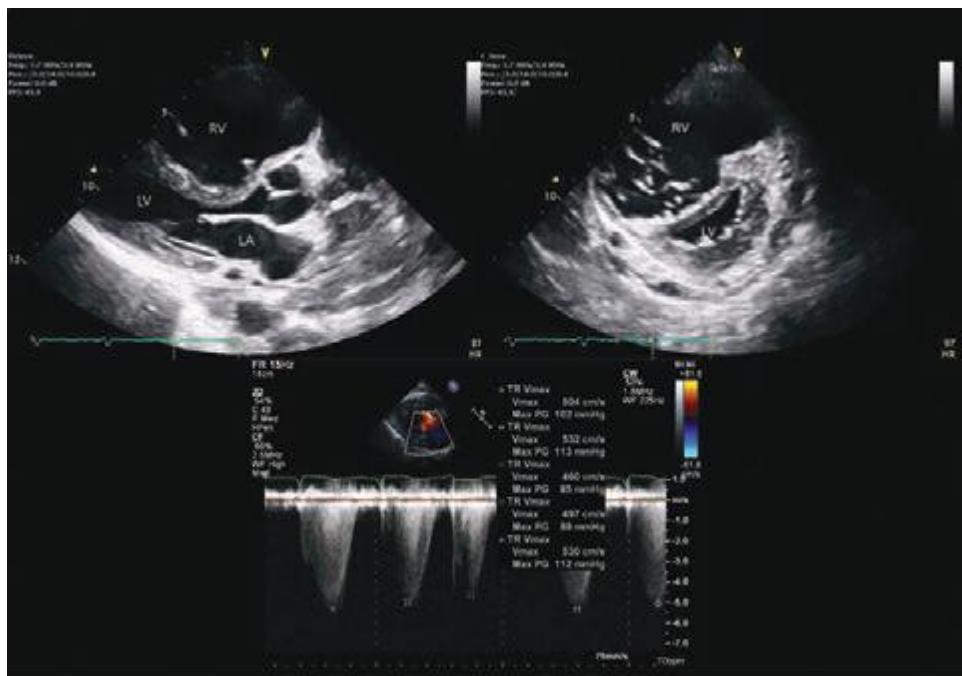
20 A 48-year-old woman with severe idiopathic pulmonary hypertension. Echocardiography reveals evidence of marked right ventricular volume and pressure overload as evidenced by enlarged right ventricle (upper left and right), small left ventricle (upper left and upper right), and flattening of the interventricular septum (D-shaped septum) in systole and diastole (upper right). Tricuspid regurgitation velocity, which reflects the pressure gradient between the right ventricle and the left ventricle, is markedly elevated at 5 m/s, consistent with a right ventricle to right atrial pressure gradient of 100 mmHg, which is consistent with systemic right-sided pressures. LA, left atrium; LV, left ventricle; RV, right ventricle. (See Videos 271e-18 and 271e-19.)
